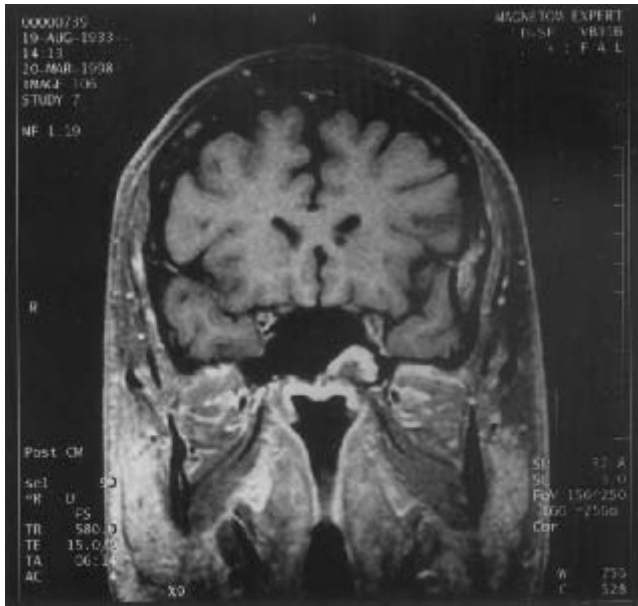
Coronal MRI-scan of the head. There is an exophytic lesion in the left sphenoid visible which extends from the sphenoid sinus floor in the direction of the cavernous sinus.
